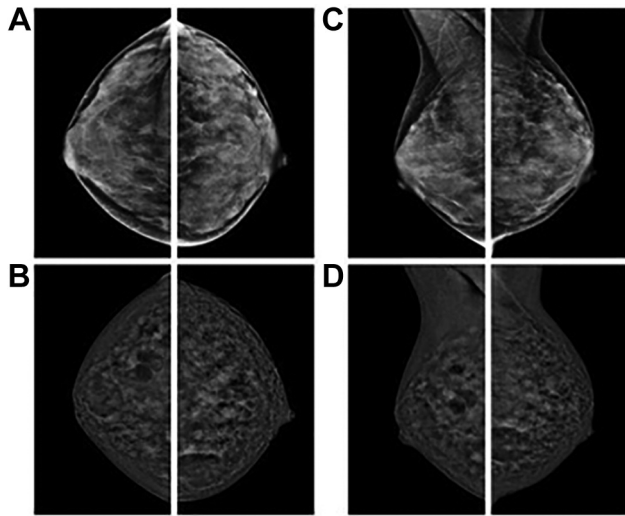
48-year-old II level CESH as II level imaging after DM and US; DM and CESH. A, C: CC and MLO digital mammography of high breast density tissue (BI-RADS D). B, D: CC and MLO CESH projections with marked BPE (grade 4). BI-RADS: Breast imaging-reporting and data system; BPE: background parenchymal enhancement; CC: craniocaudal projection; DM: digital mammography; MLO: mediolateral oblique projection; US: ultrasound contrast; CESH: contrast enhanced spectral mammography.
